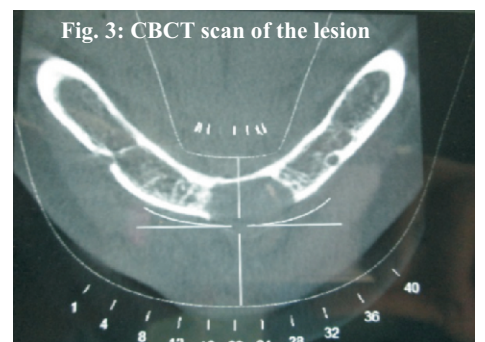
CBCT scan of the lesion
